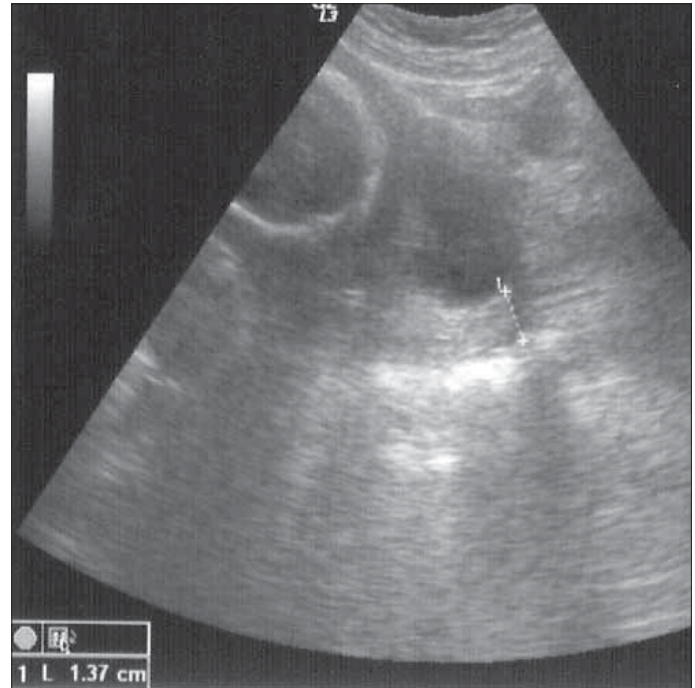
Precerclage ultrasound measurement of cervical length in case 2 (1.37 cm)
